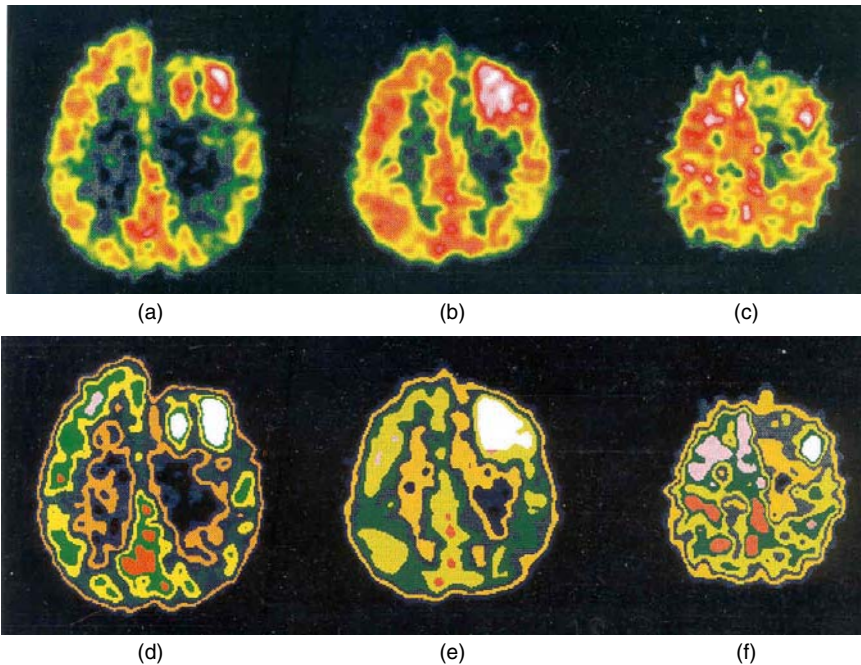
Segmentation of FDG-PET images of a patient obtained two weeks after surgery. (a)–(c) are the three slices where the tumour is evidenced by the CT. (d)–(f) are the corresponding segmented images. (Reprinted with permission from ref.<sup>5</sup>).
